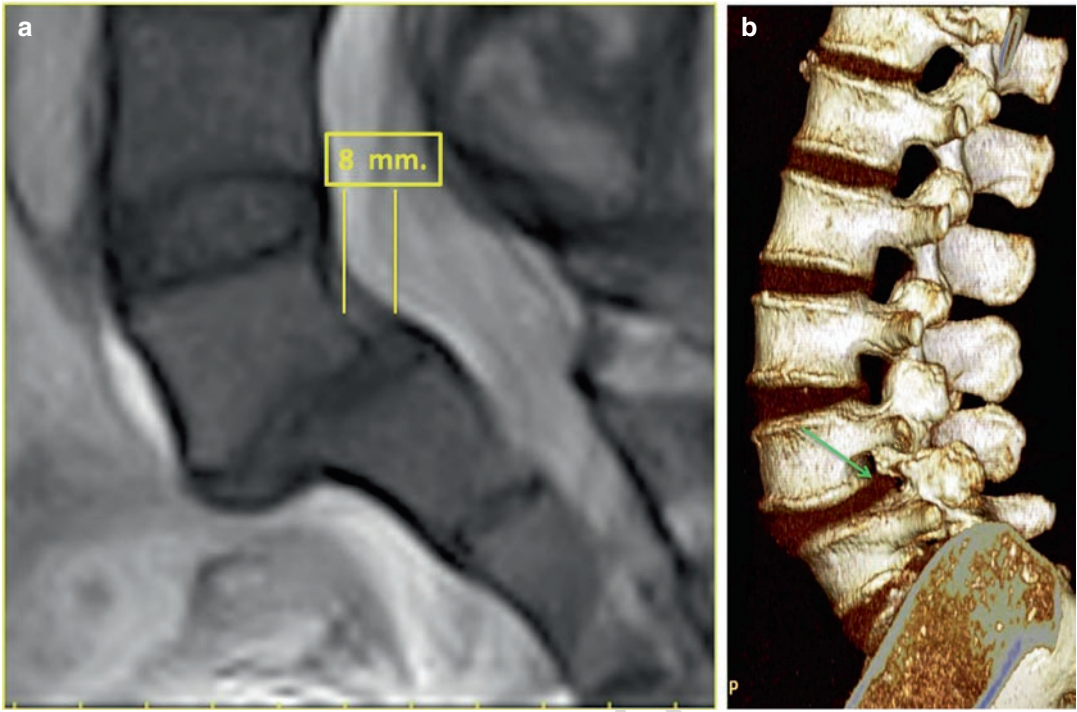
(a, b) Dynamic upright MRI scans acquired with the spine in flexion and extension. The severe anterolisthesis of L5 on S1 is not depicted by CT
